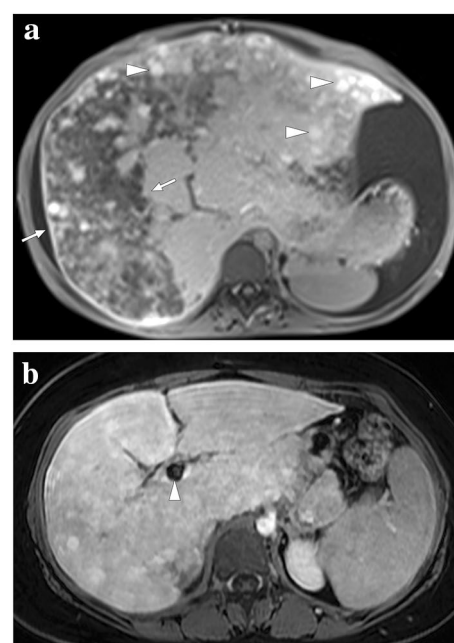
A 19-year-old female patient with known Budd–Chiari syndrome secondary to essential thrombocytosis. a Axial plane postcontrast MR image showed peripheral hypoperfused parenchyma within the right liver lobe (arrows). Also noted were ascites and multiple regenerative parenchymal nodules (arrowheads). The patient subsequently underwent a direct intrahepatic portocaval shunt procedure. b Contrast-enhanced MRI 18 months after the initial presentation showed almost complete homogenization of the liver parenchyma and disappearance of ascites. Note was also made of the intrahepatic portocaval shunt (arrowhead)
